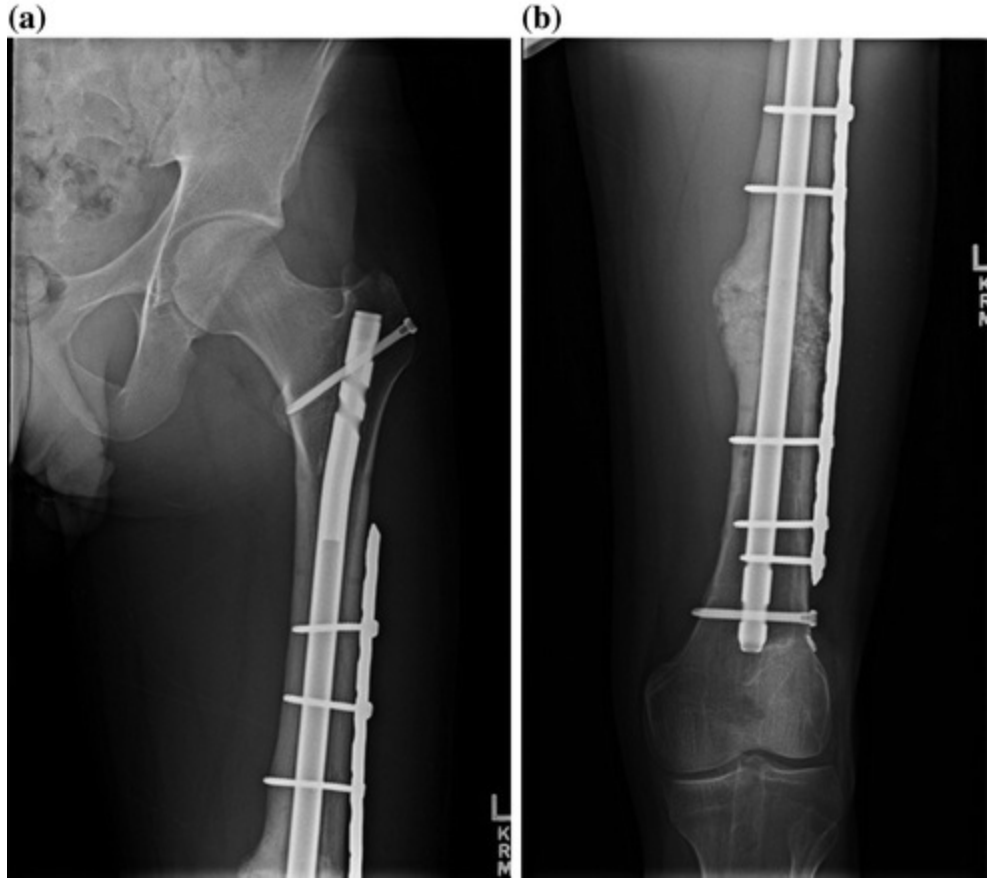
Immediate postoperative femur X-rays after compression plating in addition to previous exchange nailing and bone grafting with nail dynamization (a, b)
